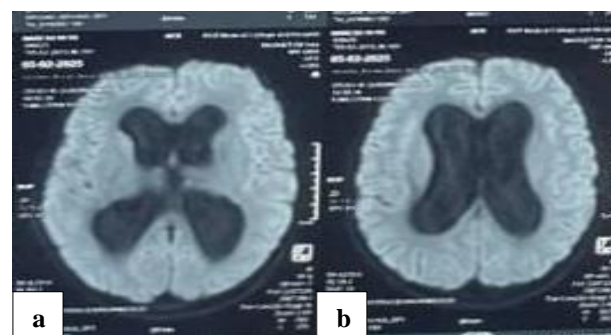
(a and b): CE MRI showing dilated ventricles.
